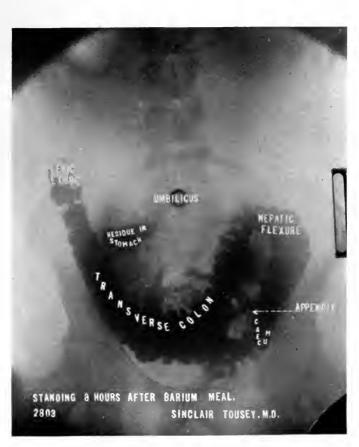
RADIOGRAPH TO DETERMINE PRESENCE OF GASTRIC OR INTESTINAL LESION REQUIRING OPERATION.
